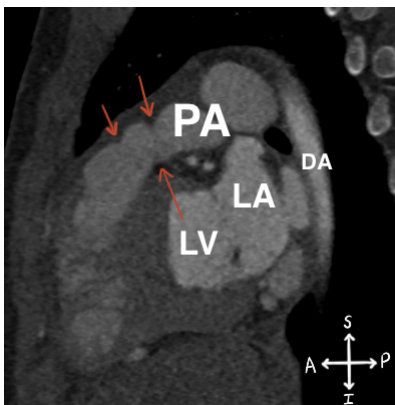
CT scan demonstrates the grooves on the exit chamber of the right ventricle (red arrows). Saggital view.
